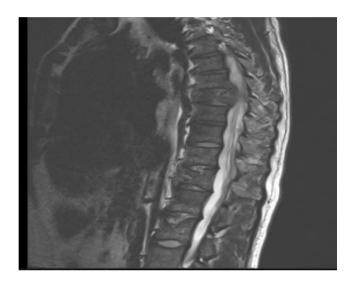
Thoracic spine MRI sagittal view image showing marked anterior wedging collapse of T6 vertebral body with subsequent retro-pulsed bony fragment seen, associated effacing of the anterior epidural fat compressing the theca causing severe canal stenosis. There is burst fracture of the T10 vertebral body with loss of the anterior vertebral body height. The fracture line breaches both the anterior and superior vertebral body cortex.
